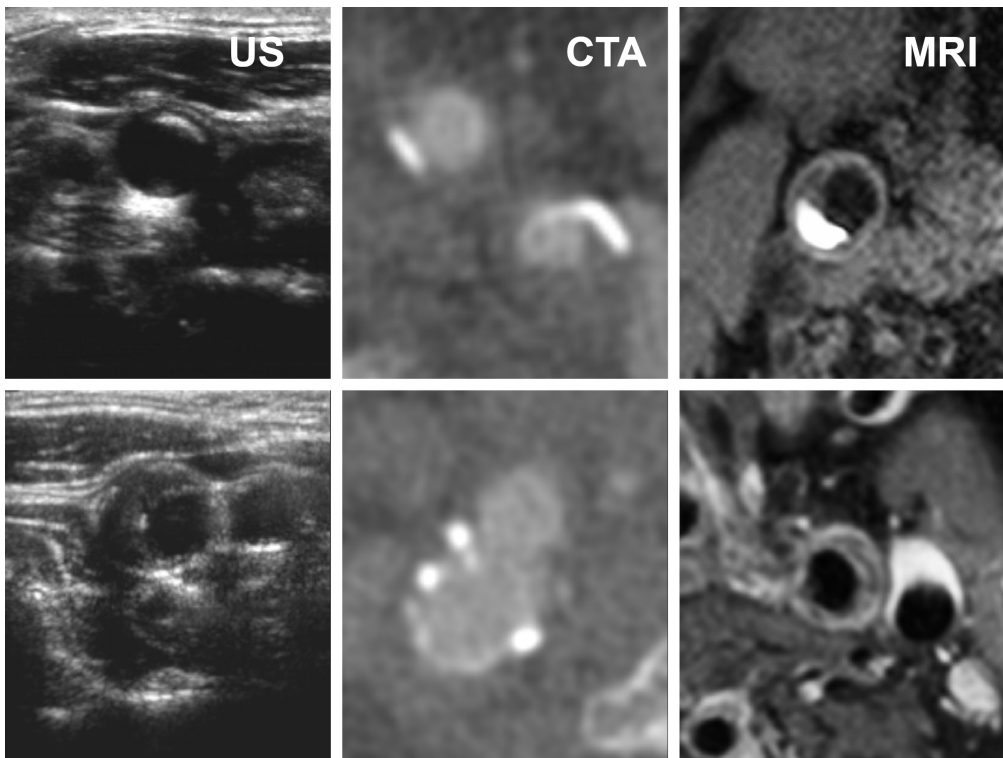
Voorbeelden van scans van halsslagaders met aderverkalking: Echo (US), CT-angiografie (CTA) en MRI. In het bovenste echobeeld heeft de plaque een hoge intensiteit, wat betekent dat het waarschijnlijk uit fibreus weefsel bestaat. De plaque in de onderste figuur heeft een lage intensiteit wat wijst op de aanwezigheid van een grote vetkern. In de CTA is kalk duidelijk te zien als witte gebieden. De vaatholte is ook duidelijk te herkennen, maar het onderscheid tussen de wand en het omliggende weefsel is lastiger te zien. De MRI in de bovenste rij heeft een gebied met intraplaque bloedingen met hoge intensiteit en een kalkregio met lage intensiteit vlak daarboven. De onderste rij laat een MRI na contrastinjectie zien waar het gebied midden in de verdikte wand donker is ten opzichte van de rand vanwege een vetkern.
